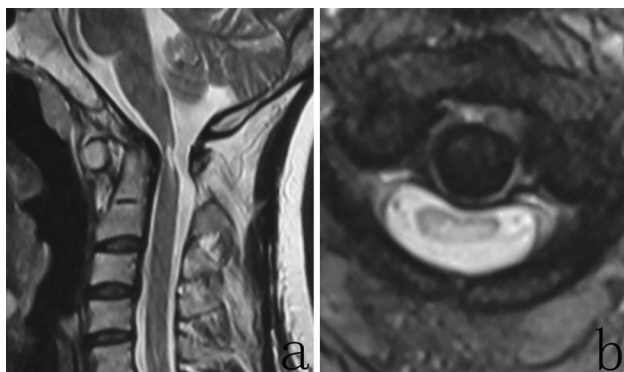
Magnetic resonance image before surgery, sagittal T2 (a), and axial T2 (b)-weighted images of the cervical spine showing spinal cord compression and intramedullary cord signal abnormality at the level of the atlantooccipitoaxial region
